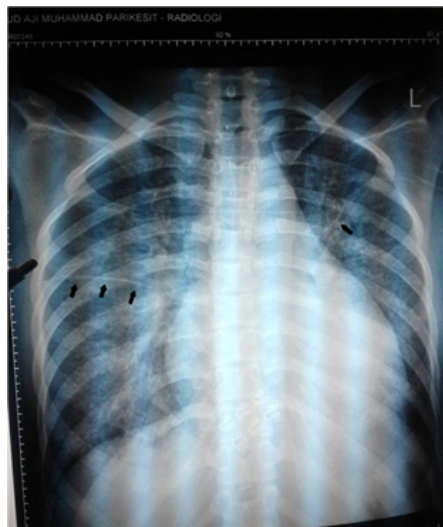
The patient's chest X-ray showed Kerley A line (black arrows), perihilar cephalization, and mild cardiomegaly. The line can be seen clearer in right lung than left lung.
